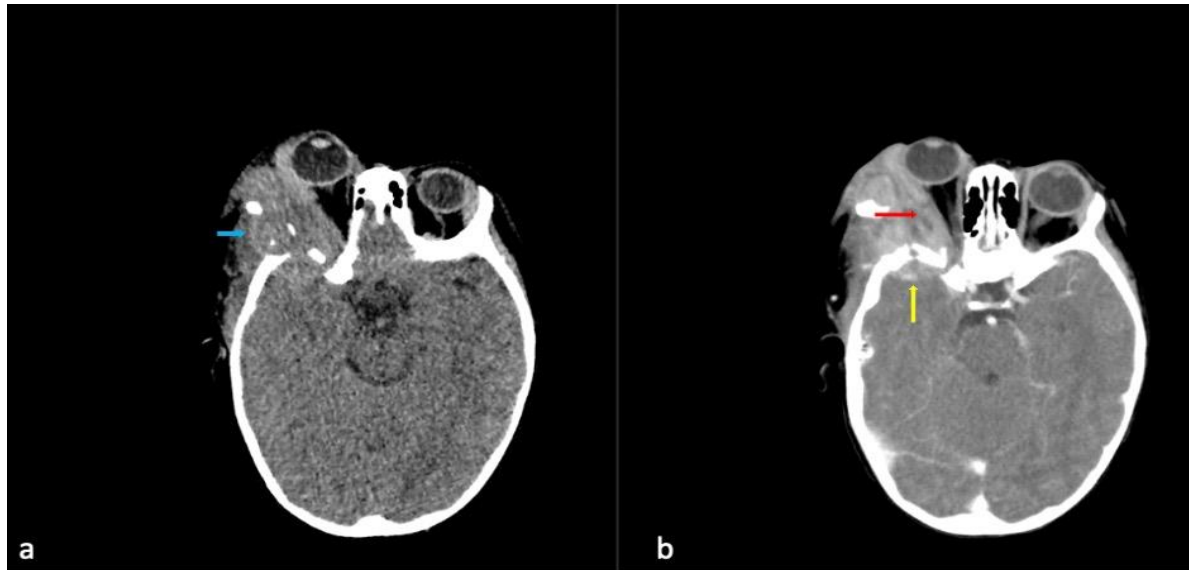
CT scans of the head
